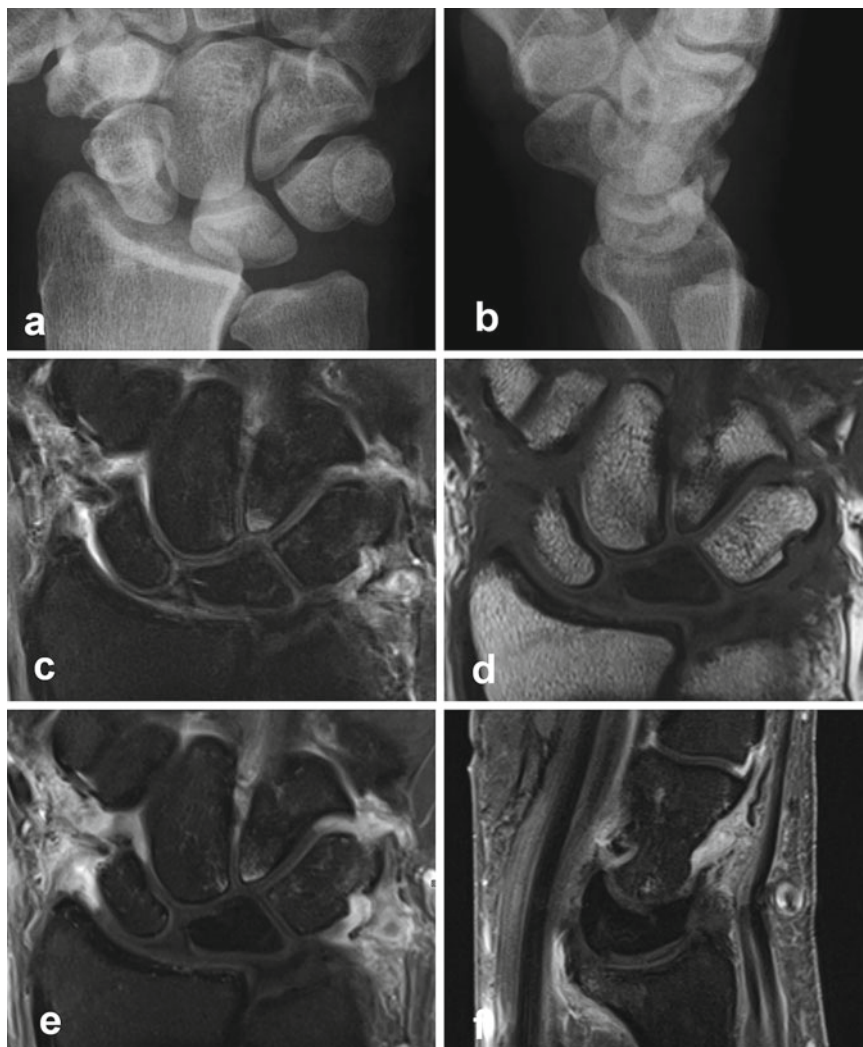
Complete lunate necrosis (MRI pattern C) in stage IIIc of Kienböck's disease. Patient is a 52-year-old male who has been suffering from severe wrist pain for 2 years. Necrosis is manifest in the absence of bone-marrow edema. (a, b) Dorsopalmar and lateral radiographs show slight lunate osteosclerosis. There is a negative ulnar variance and suspicion of a dorsal pole fracture. (c) The lunate is without any evidence of bone-marrow edema. The proximal pole is flattened, and horizontal fracture
